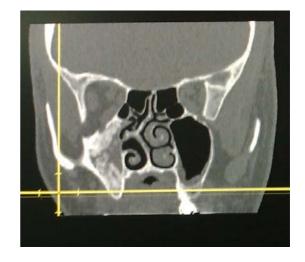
CT scan: mixed opacity of radiolucent and radioopaque material in the maxillary sinus
